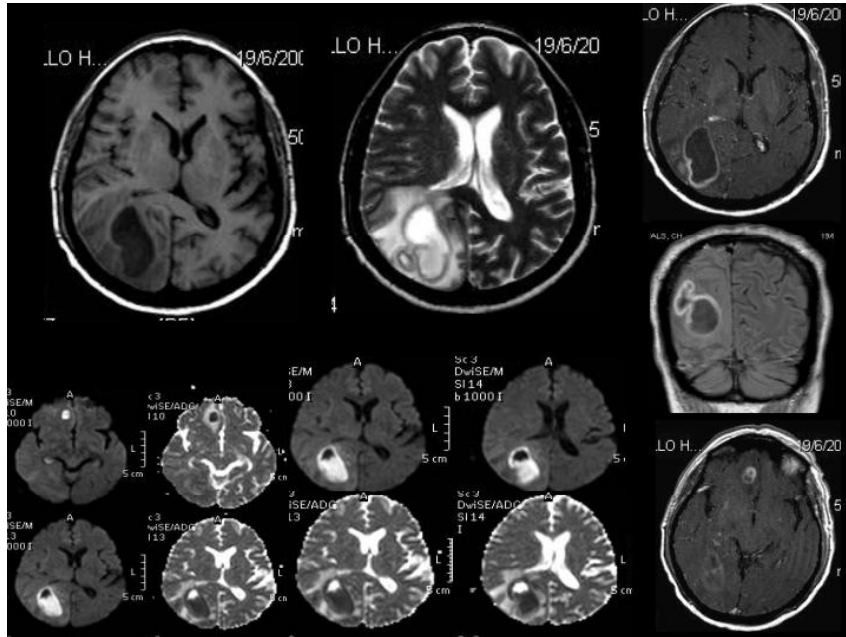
MRI shows two (one occipital and one at frontal lobes) peripheral enhancing cystic lesions with central hyperintense area and hypointense rim on T2 WI and restricted area on DWI suggestive of abscess
